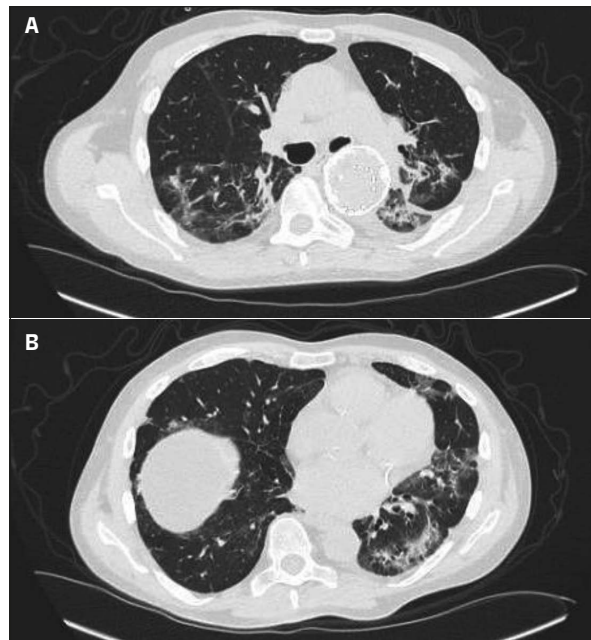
High-resolution computed tomography performed 34 days after hospital admission.
